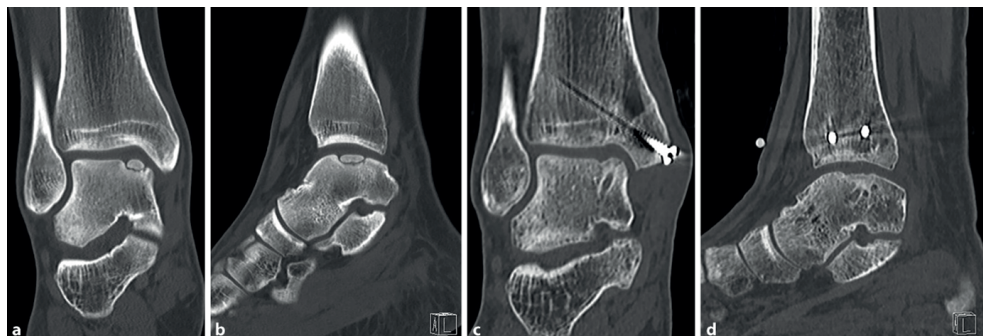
Preoperative (a,b) and 1-year postoperative (c,d) CT scan of LDFF in a large OCL with a fragment. Two bioabsorbable screws were used to achieve a stable fragment fixation as a whole. At 1-year postoperatively, good union of the fragments and consolidation of the osteotomy had occurred. Of note, the postoperative radiolucency below the fragment is the bioabsorbable screw.
